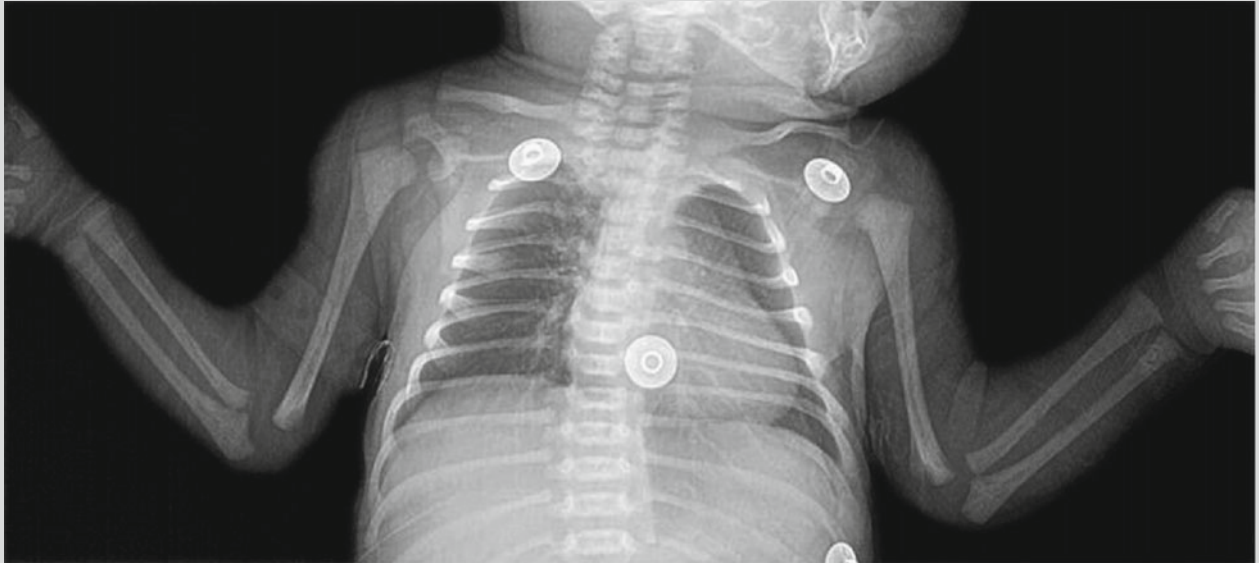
Syphilitic metaphysitis. X-ray demonstrates round-like low-density bone lesion at the right inferior humerus
